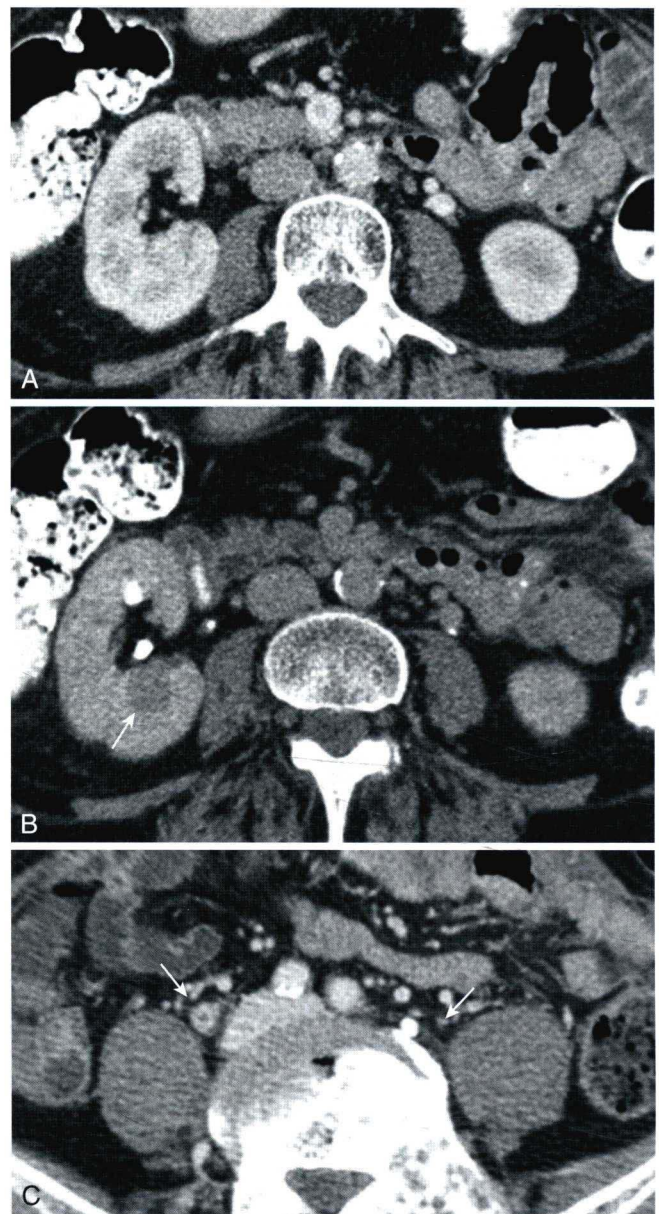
Computed tomography urogram (CTU) images show advantage of the nephrogram phase. A, Scan through the kidneys during the cortico-medullary phase and no renal mass is detectable. B, During the nephrogram phase a 1.5 cm mass (arrow) is readily visible in the right kidney. This was biopsied before ablation and proven to be a renal cell carcinoma. C, In another patient, scan through the mid ureters (arrows) shows a thickened and avidly enhancing area in the right ureter that was biopsied and proven to be a urothelial carcinoma. The nephrogram phase is optimal for renal parenchymal mass and malignant urothelial mass detection.
